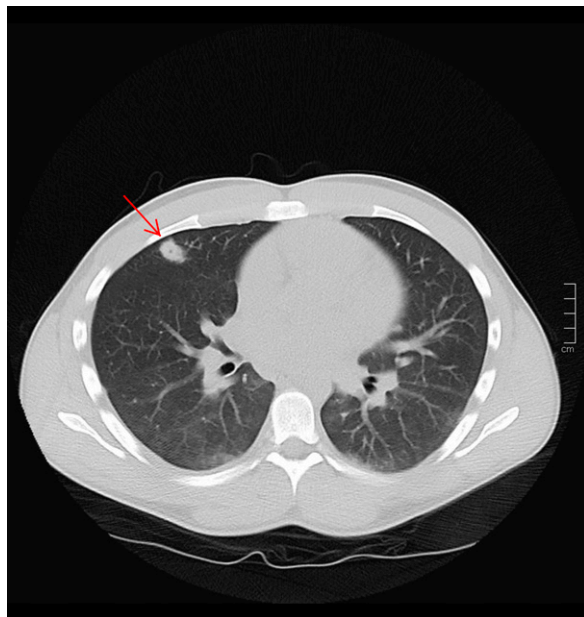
Axial computed tomographic scan of the thorax demonstrates an ovoid nodule (red arrow) in the right middle lobe with a small focus of central cavitation suspicious for a septic embolus.
